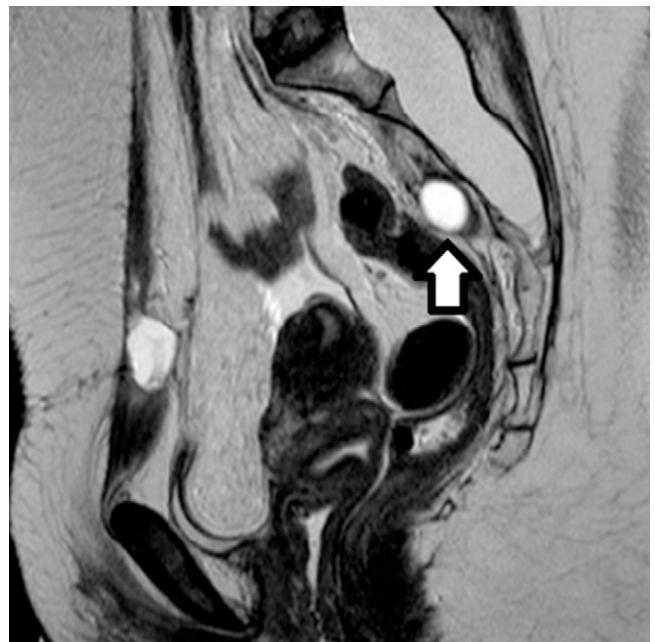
Abdominal T2-weighted MRI showing resolution of the meningocele with a small residual lesion not connected to the subarachnoid space (arrow).
